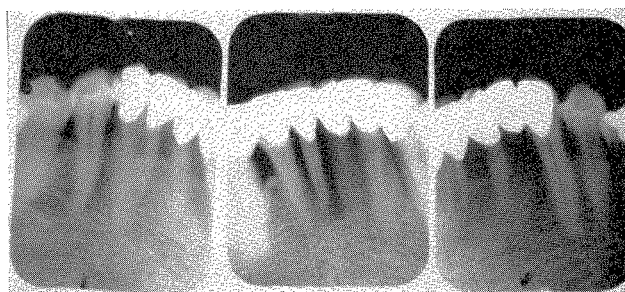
The roentgenograms of the completed work. The alveolar bone destruction between the central incisors can be seen. It will now be given a chance to heal.
